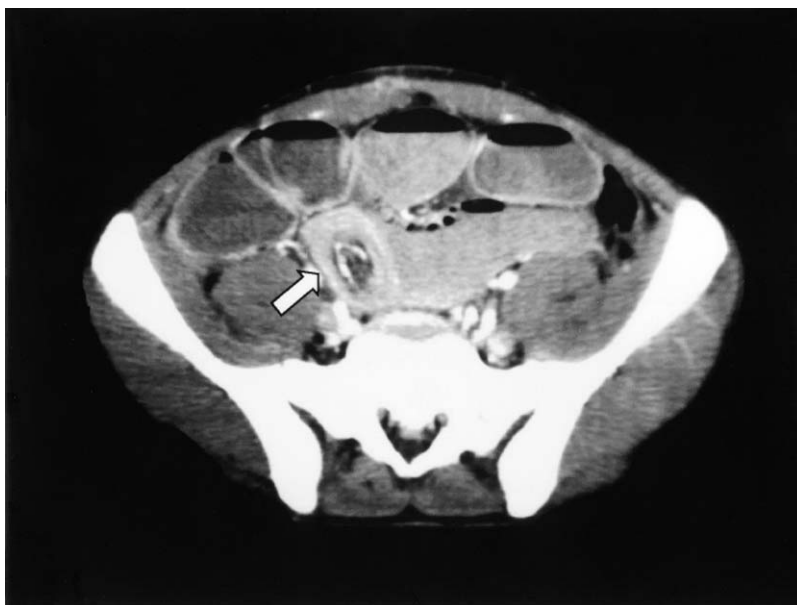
CT scan demonstrating enteroenteric intussusception (arrow).
